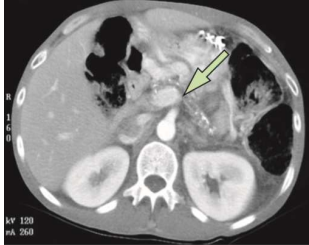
Abdominal CT showing pancreatic calcification, atrophy and a dilated pancreatic duct.
